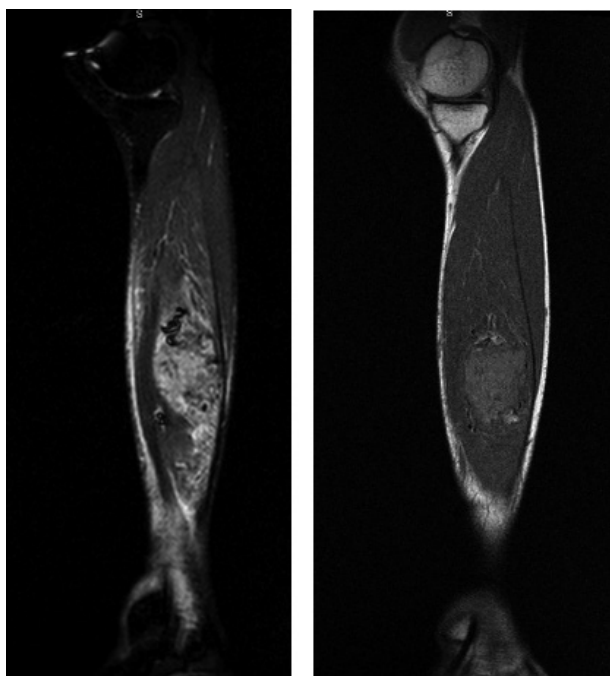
MRI T2W (a) and (b) sequences : demonstrating typical alveolar appearances of the tumour in the soleus muscle bulk.
